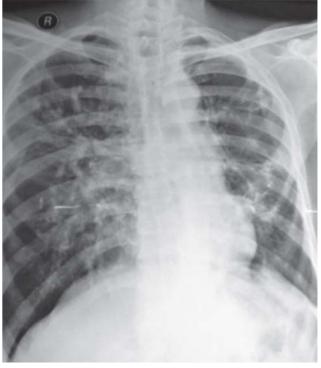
Chest radiograph (postero-anterior view) showing bilateral infiltrates.
